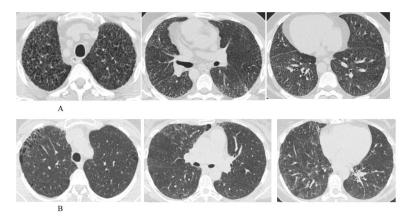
HRCT images of patients classified as S-ILD A: Case BR-8 showing emphysema and reticulation;
